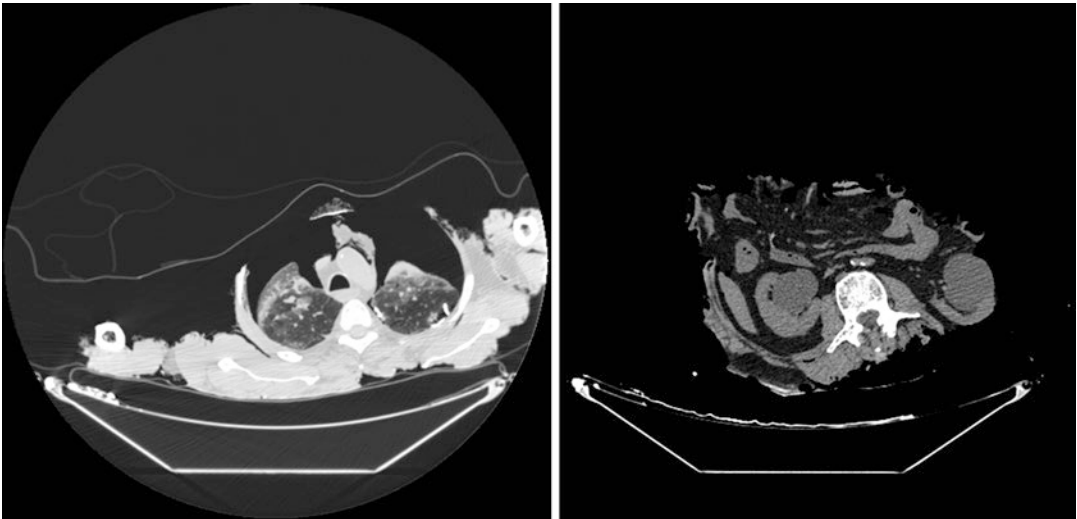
Axial noncontrast computed tomography (CT) scans showing grave cutaneous and osseous losses due to burn lesions
